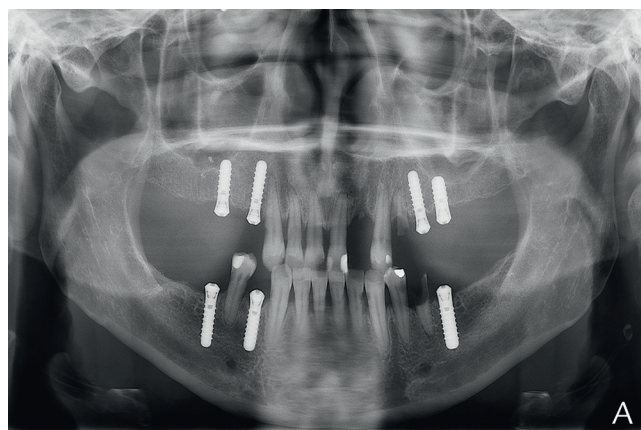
Patient #3 initial situation. A, Panoramic radiographs. B and C, Intraoral view of edentulous maxilla and mandible with implants in situ.
